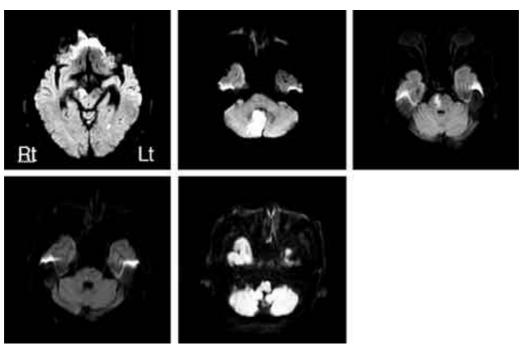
Diffusion weighted MR images of patients who showed no VEMP abnormalities(1 midbrain, 1 cerebellum, 2 pons, 1 medulla lesion).
